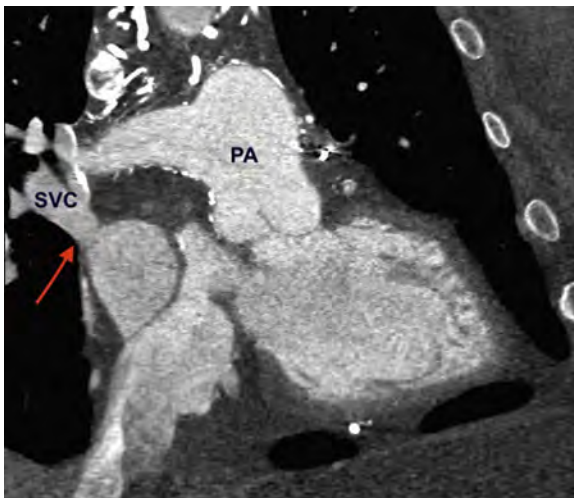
This 2D image from CT performed in a patient after an AtrSO demonstrates complete occlusion of the SVC limb of the systemic venous baffle (red arrow), with opacification via collateral vessels to the IVC from an arm injection. PA, Pulmonary artery.
